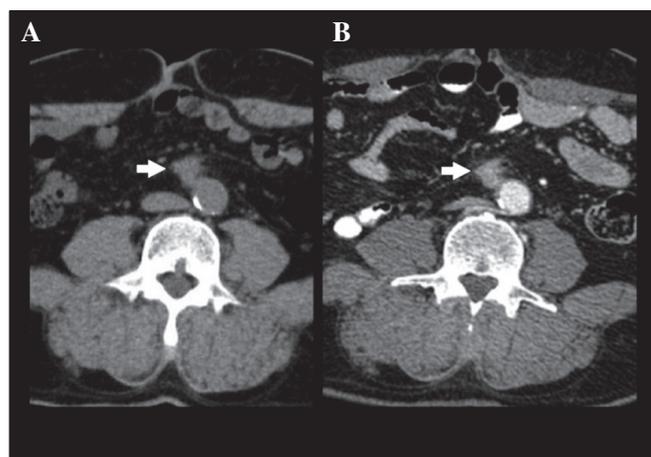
Abdominal CT scan without (A) and with (B) an intravenous contrast agent where a retroperitoneal nodule (arrow) may be seen adjacent to the aorta, displaying an irregular contour and homogeneous contrast enhancement.
